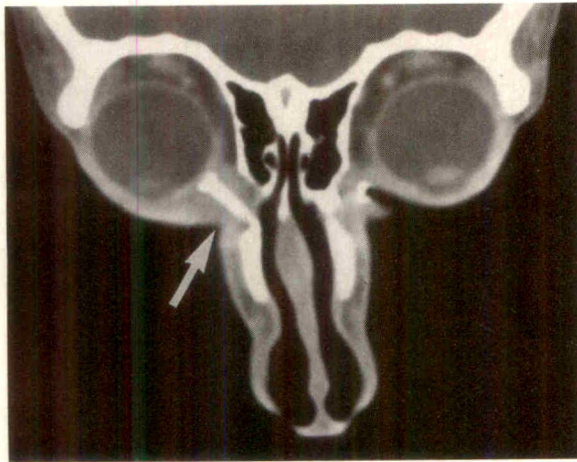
(Bartley and Gustafson). Case 1. Computed tomographic scan from neurologic evaluation shows soft tissue swelling around right Jones tube (arrow).
